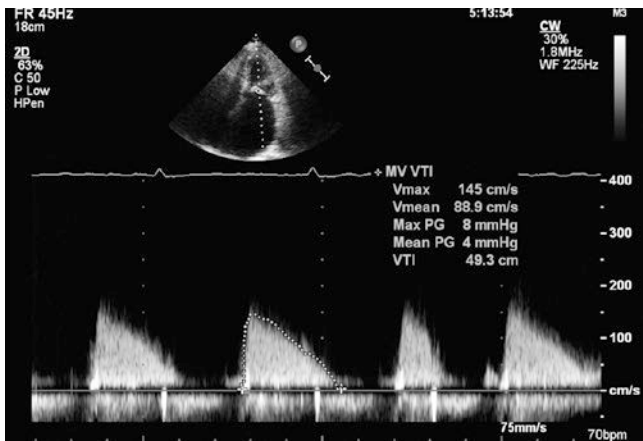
Continuous wave Doppler should be utilized to assess mitral gradients. In this example, there was a mean mitral valve gradient of 4 mmHg
